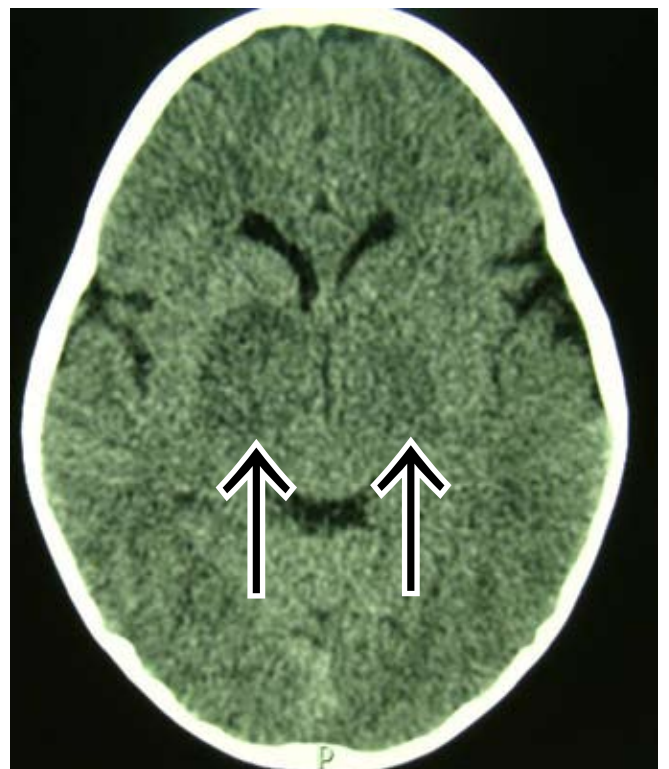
Axial non-enhanced brain CT demonstrating bilateral low-density lesions in the basal ganglia with no appreciable mass effect.
